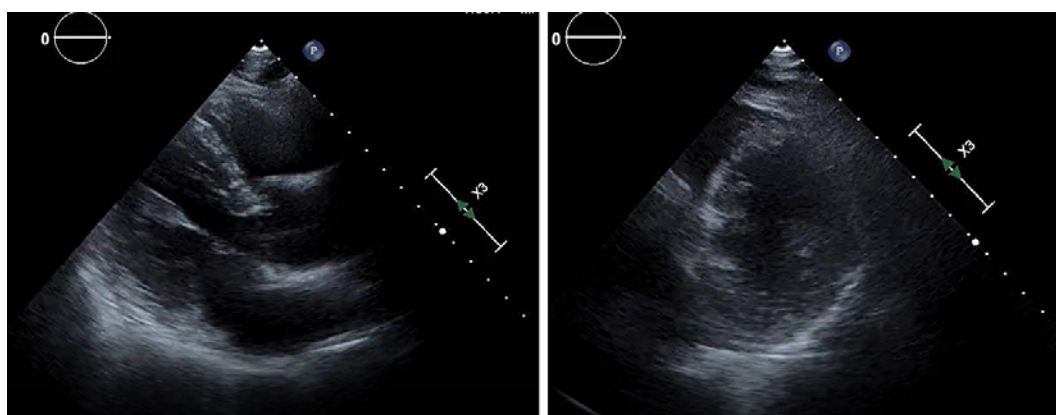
Transthoracic echocardiography showed normal left ventricular function with an ejection fraction of 60% and only slight pericardial effusion.
